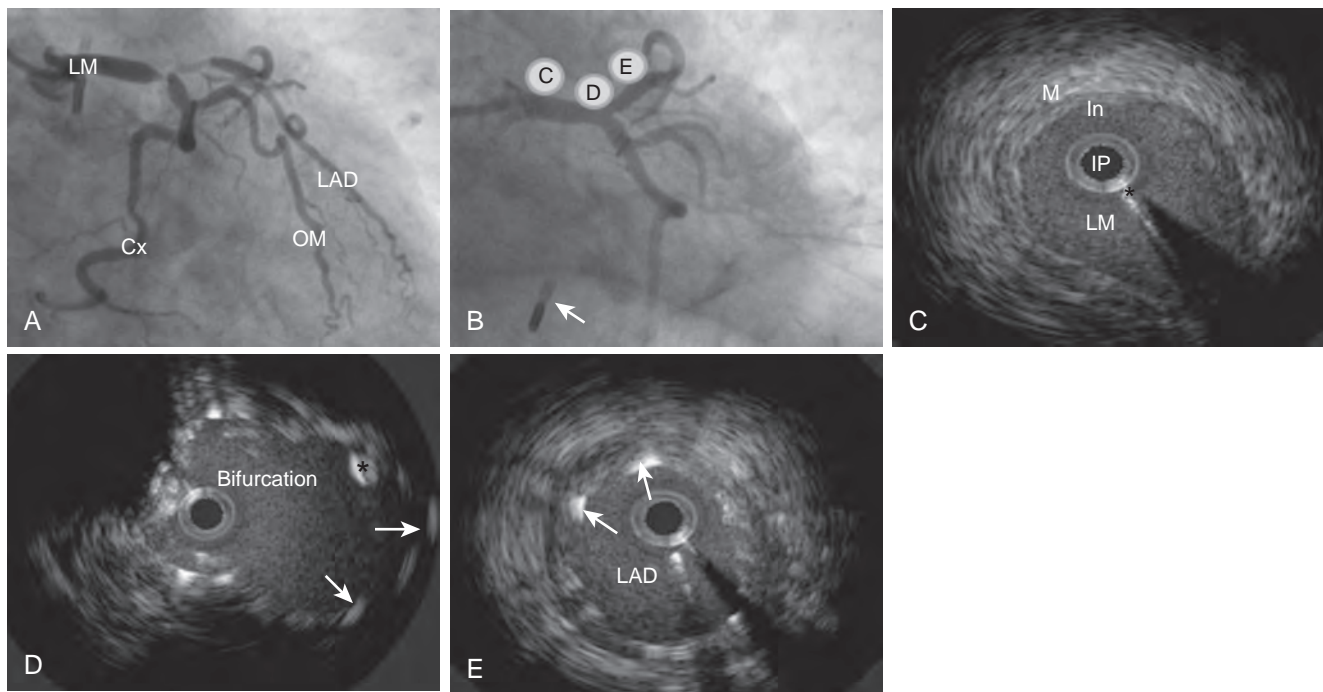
Intravascular ultrasonography (IVUS) for assessment of human coronary arteries. (A) Right anterior oblique projection of the left coronary circulation. The left main coronary artery (LM), left anterior descending coronary artery (LAD), circumflex artery (Cx), and obtuse marginal artery (OM) are seen. Severe distal LM stenosis is seen bifurcating into the LAD and Cx. (B) Postpercutaneous intervention angiogram demonstrates no residual stenosis. Drug-eluting stents were placed in the LM, LAD, and Cx. The tip of an aortic balloon pump can be seen (arrow). Letters indicate the location of IVUS images for correlating panels. (C–E) IVUS images of the LM, LM bifurcation, and LAD, respectively. Arrows, Stent struts; asterisk, guidewire; In, intima; IP, IVUS probe; M, media.
